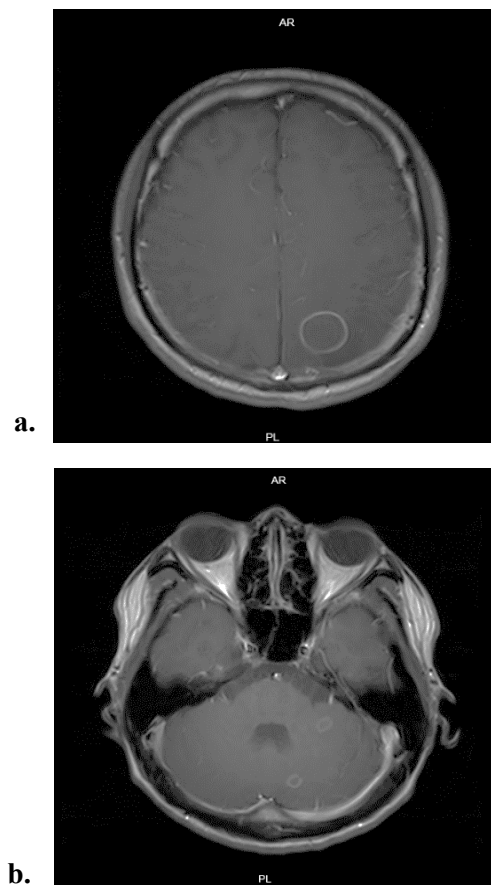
A contrast-enhanced MRI of the head shows multiple well-defined round intra-axial lesions
